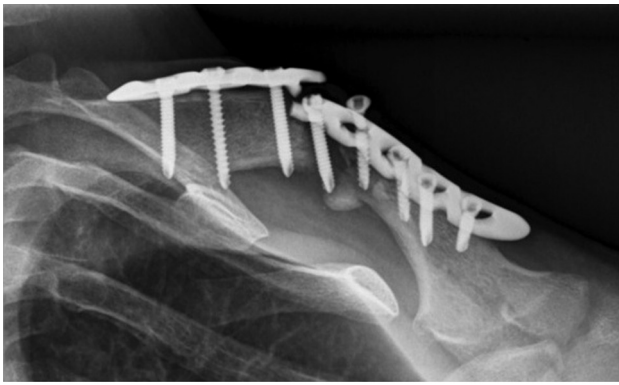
Pre-operative X-rays showing the atrophic non union of the left clavicle with implant failure.
